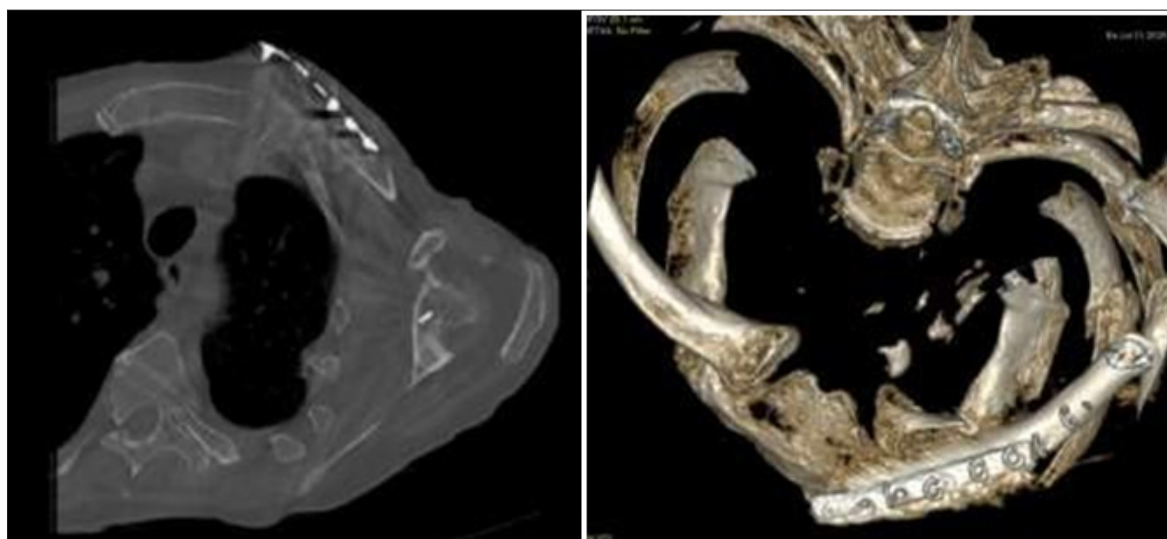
Control CT axial section 1 month postoperatively
